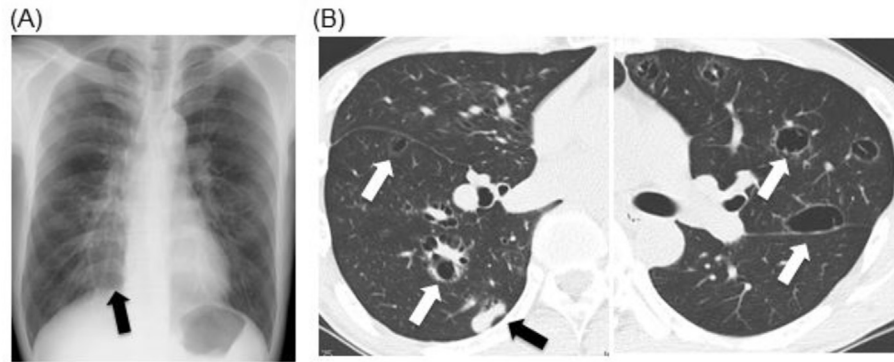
Chest radiography and computed tomography obtained on admission. (A) Chest radiograph shows ground glass opacity in the right lower lung field (black arrow). (B) Chest computed tomography shows multiple cysts (white arrows) and nodules (black arrow) on both lungs.
